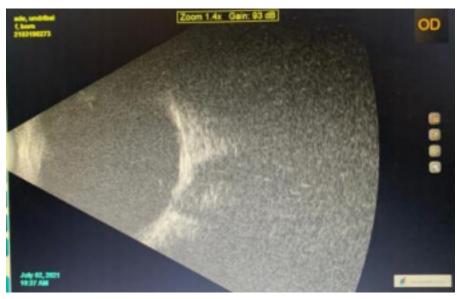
B-scan ultrasound showed no abnormality in posterior segment.
